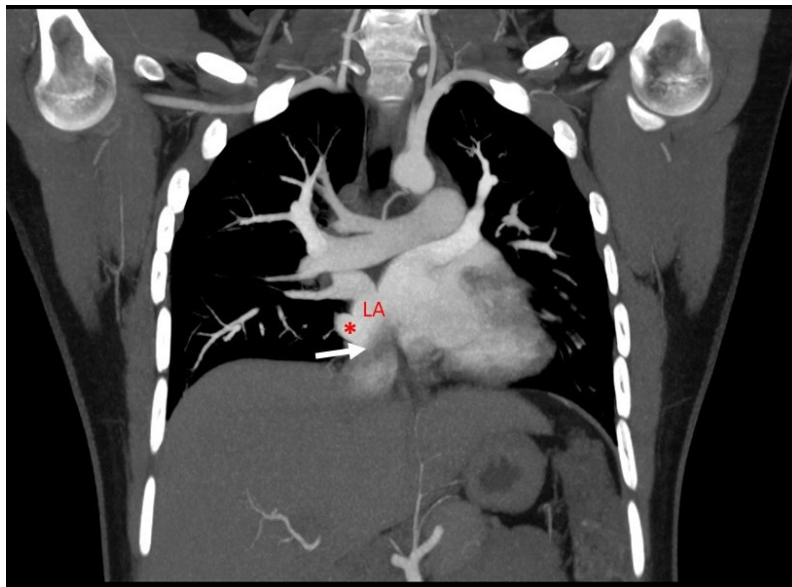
CT Angiography Coronal MPR image- IVC (white arrow) seen opening into left atrium (LA) close to opening of right inferior pulmonary vein (red star).
